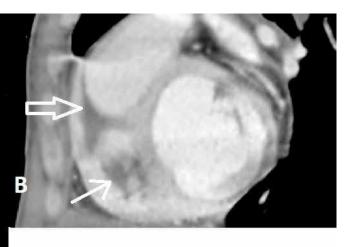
Cardiac computed tomography demonstrates thrombotic right ventricular mass located mostly near tricuspid valve (thick arrows) and obliterating right ventricular apex (thin arrows). Note that the mass almost completely obliterates right ventricular cavity
